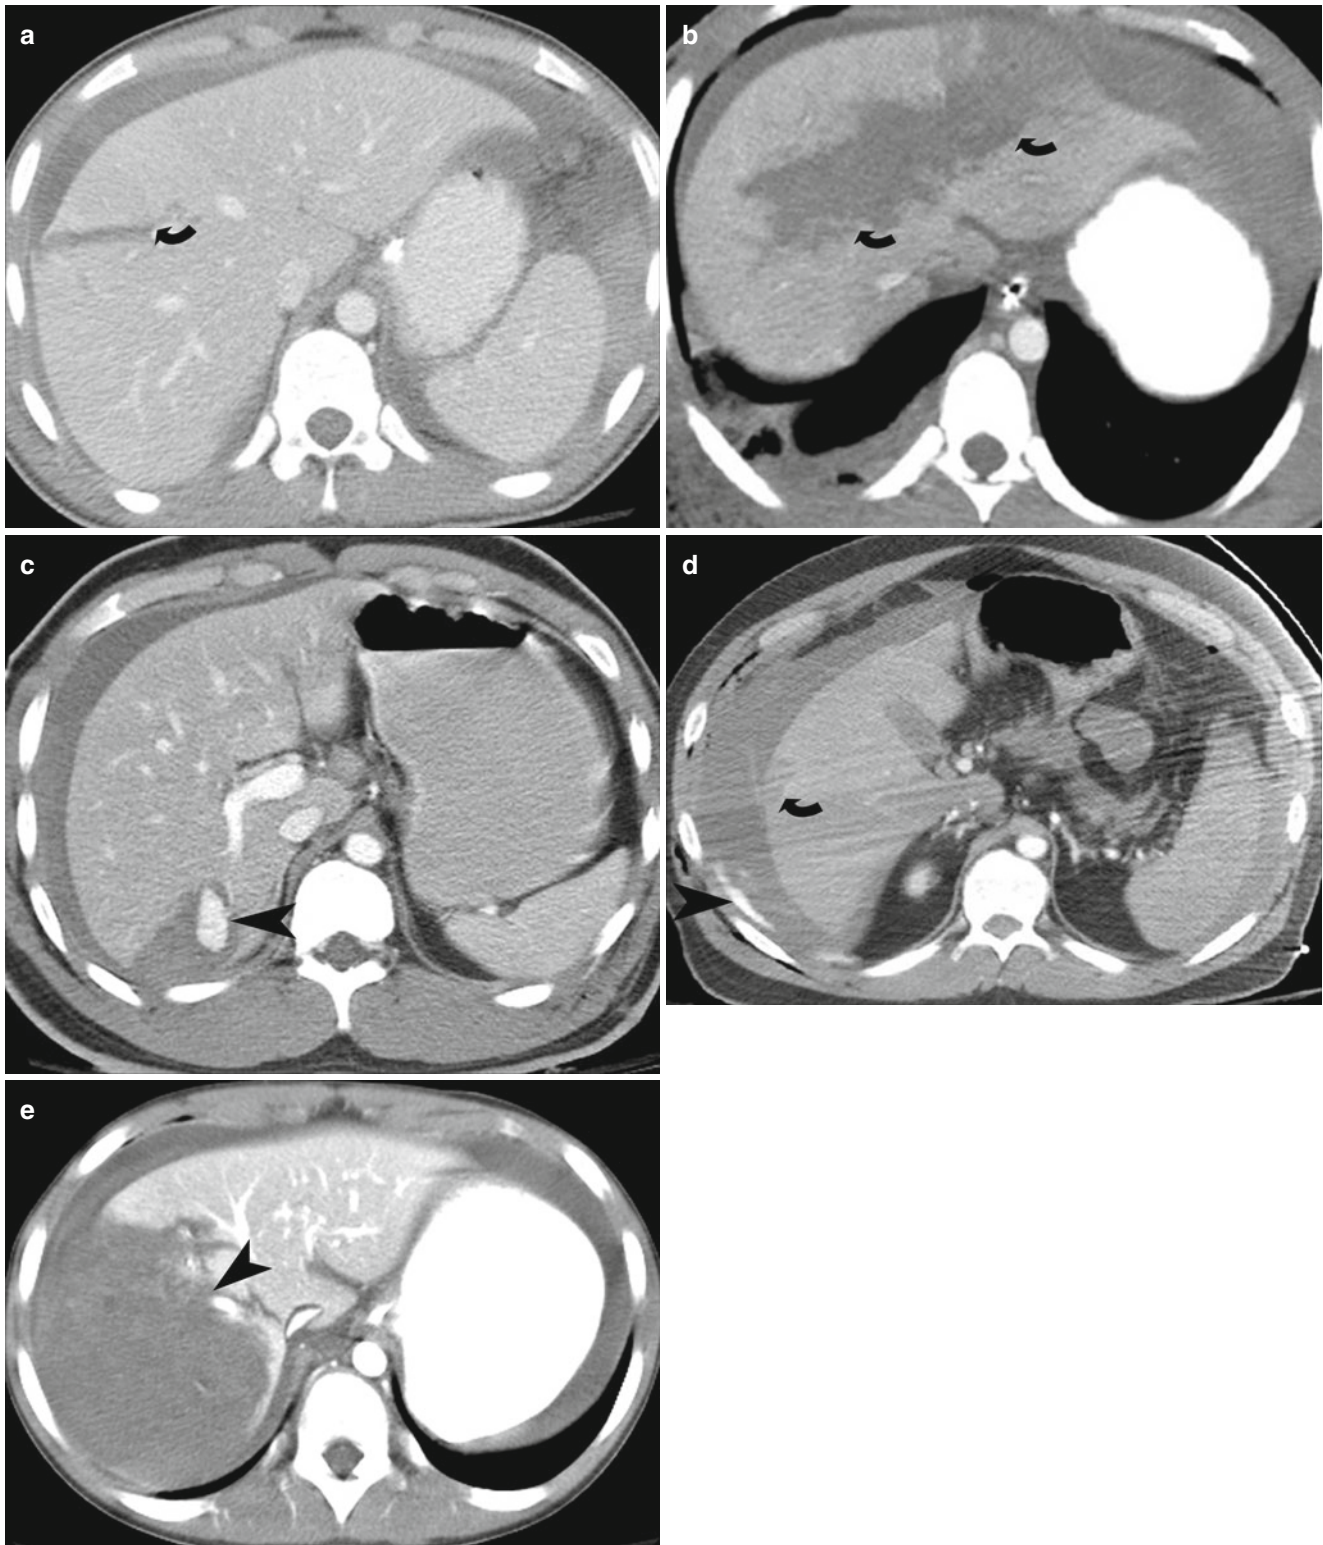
Hepatic lacerations. (a and b) Contrast-enhanced CT in two different patients show a deep (>3 cm) hepatic laceration (grade III and grade IV liver injury) (*curved arrows*) due to stab injury. (c) Contrast-enhanced CT shows a wedge shaped liver laceration due to stab injury with subcapsular hematoma and enhancing pseudoaneurysm (*arrowhead*).
